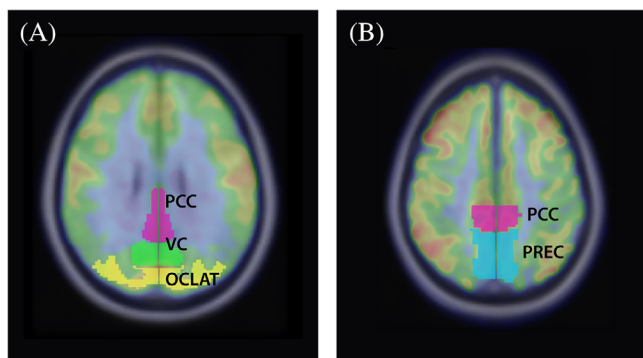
Volumes of interest (VOI) for the definition of different cingulate island ratios. (A, B) Fused ¹⁸F-FDG-PET/MRI images in axial plane. VOI definition was based on an MRI template. OCLAT, lateral occipital cortex (yellow); PCC, posterior cingulate cortex (magenta); PREC, precuneus (blue); VC, visual cortex (green)
